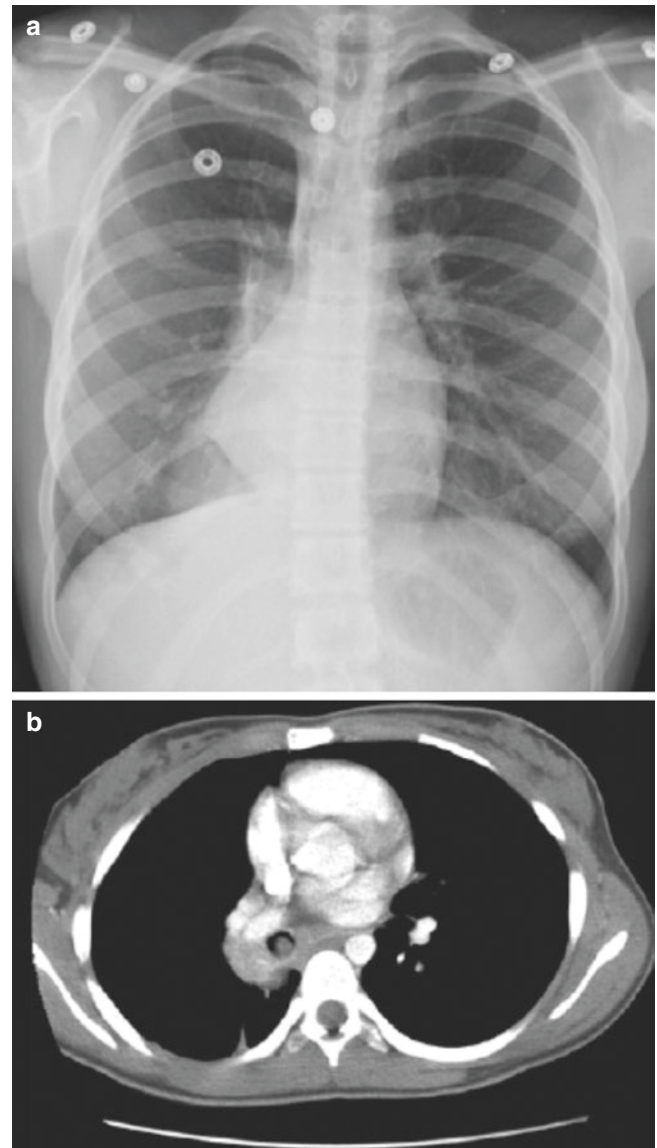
A 15-year-old girl with an endobronchial carcinoid tumor who presented with cough. (a) Frontal chest radiograph shows an opacity in the right lower lobe with volume loss likely representing atelectasis. (b) Axial enhanced CT image shows a well-circumscribed endobronchial mass. At bronchoscopy, the patient was found to have an endobronchial carcinoid tumor
